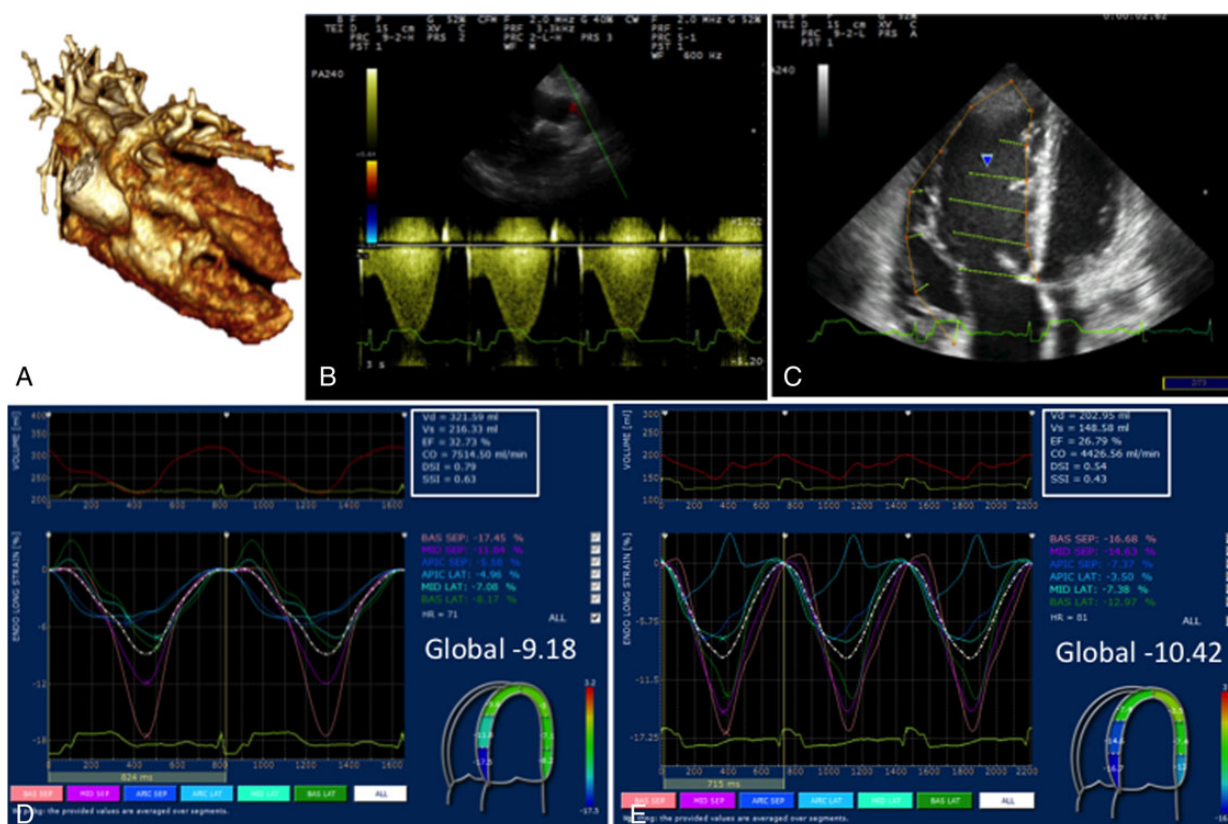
Right ventricular longitudinal strain in a 30-year-old patient with stenosis of the RV-to-PA conduit. (A) 3D reconstruction of the heart. (B) Echo Doppler shows severe conduit stenosis. (C) Tracking points position on subendocardial fibres to analyse the strain. (D) Report of strain values by segments before implantation of a pulmonary valve into the conduit. (E) Report of strain values by segments 3 days after implantation of a pulmonary valve into the conduit. Strain values are ordered according to a left ventricle four-chamber template for which the label of septal segment refers to lateral wall and those of the later wall refer to septal segments. In patients with RVOT stenosis, the strain values are very low and do not change much after pulmonary valve replacement in the short-term follow-up; however, quantitative data showed significant reduction of RV volume and normalization of the cardiac output (see white box).
